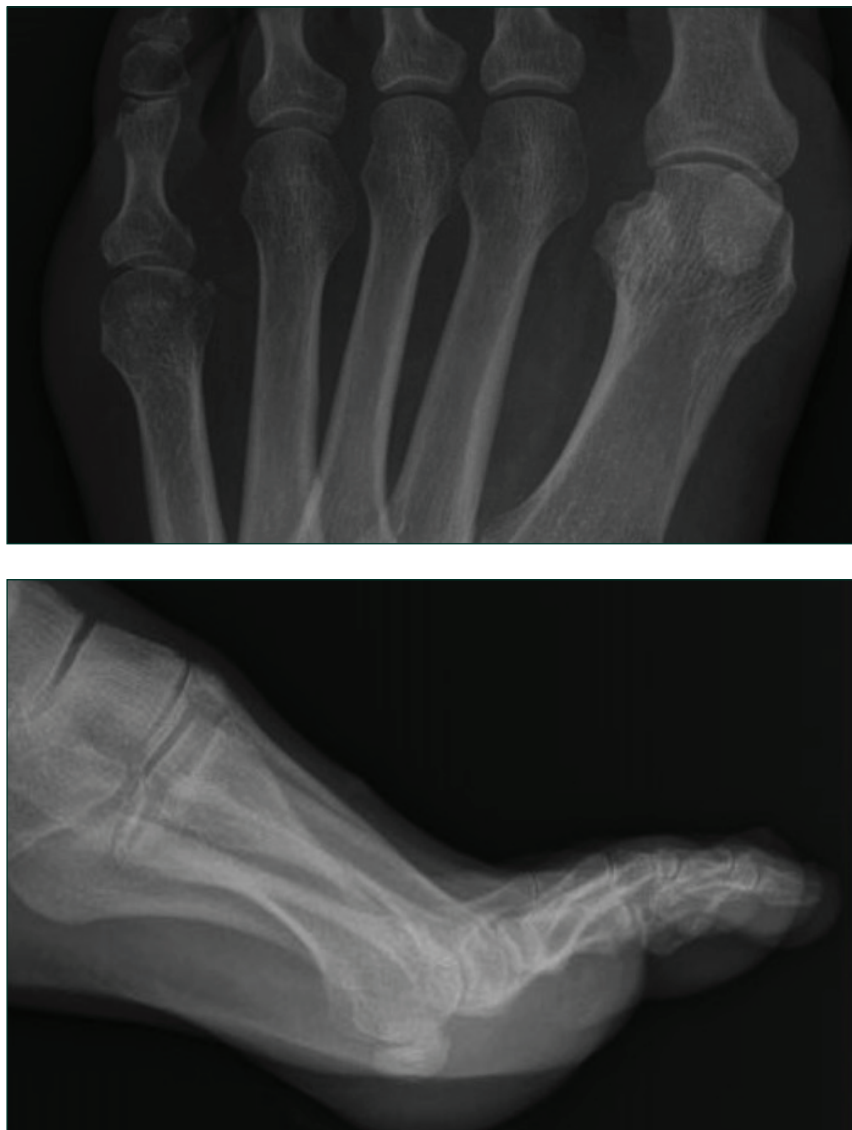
Left foot X-rays showed no signs of osteomyelitis or soft tissue gas.
